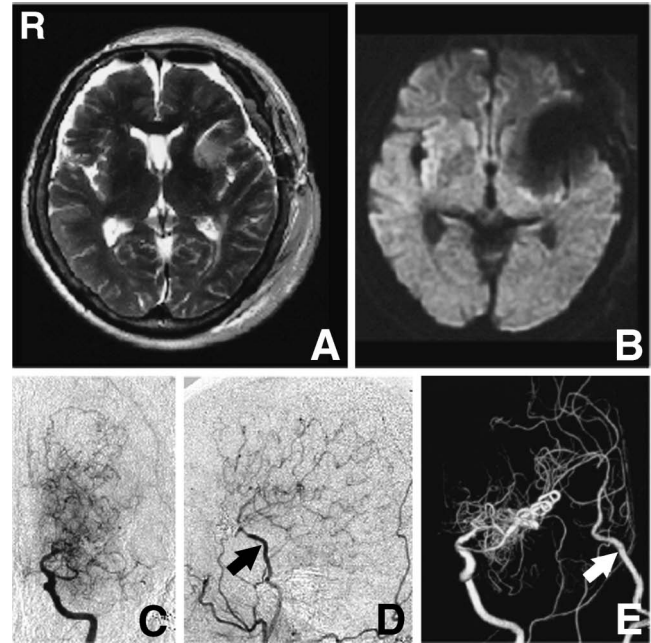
A, B: T₂-weighted (A) and diffusion-weighted (B) magnetic resonance images obtained on the day after surgery showing no ischemic or hemorrhagic complications. C-E: Left internal carotid angiogram (C), left external carotid angiogram (D), and three-dimensional digital subtraction angiogram of the left common carotid artery (E) obtained 6 months after surgery showing no aneurysm filling, patent superficial temporal artery-middle cerebral artery bypass (arrow), and no antegrade blood flow from M₁ due to the contribution of the bypass flow to the distal middle cerebral artery territory.
